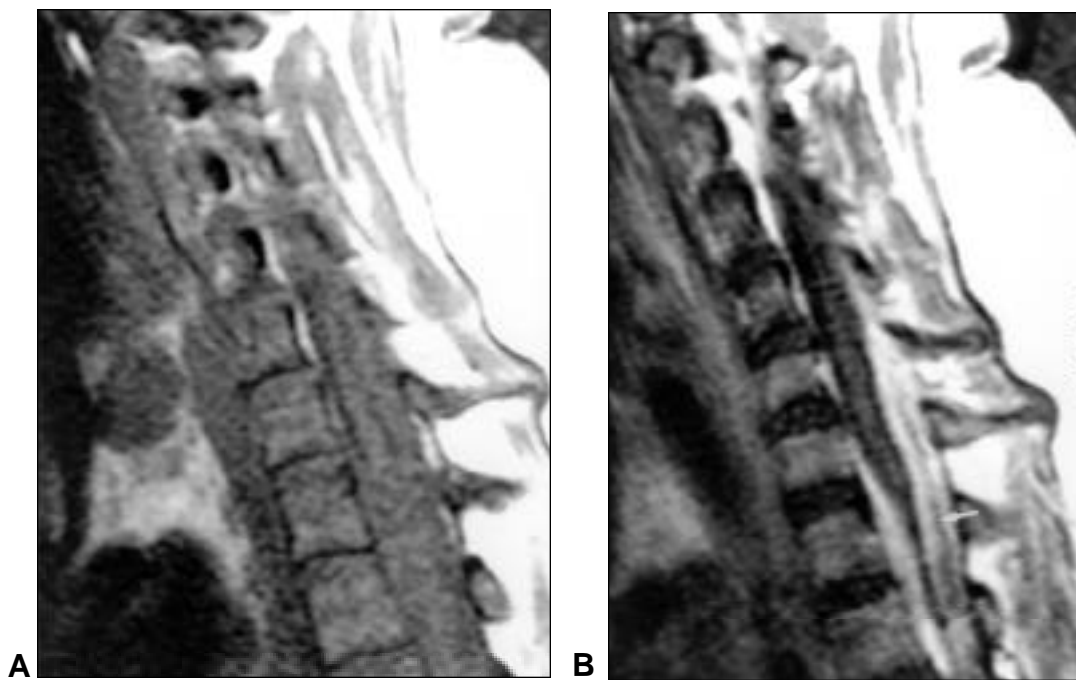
Patient 2. Sagittal T1-weighted images before (A) and after administration of intravenous Gd-DTPA (B). On the pre-contrast image, spinal cord and dura are isointense and difficult to distinguish. The abnormally thickened dura shows marked contrast enhancement. The enhancement is more marked peripherally with some relative signal hypointensity centrally (arrow).
